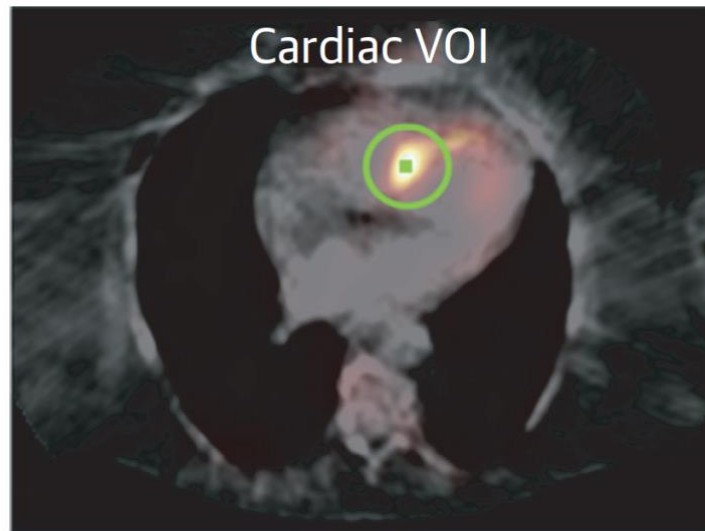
SUV quantification using a region of interest over the brightest part of the cardiac uptake. Adapted from our work [186]
